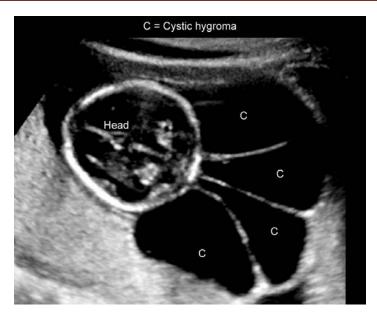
Ultrasound of cystic hygroma of neck. It is multilocular
